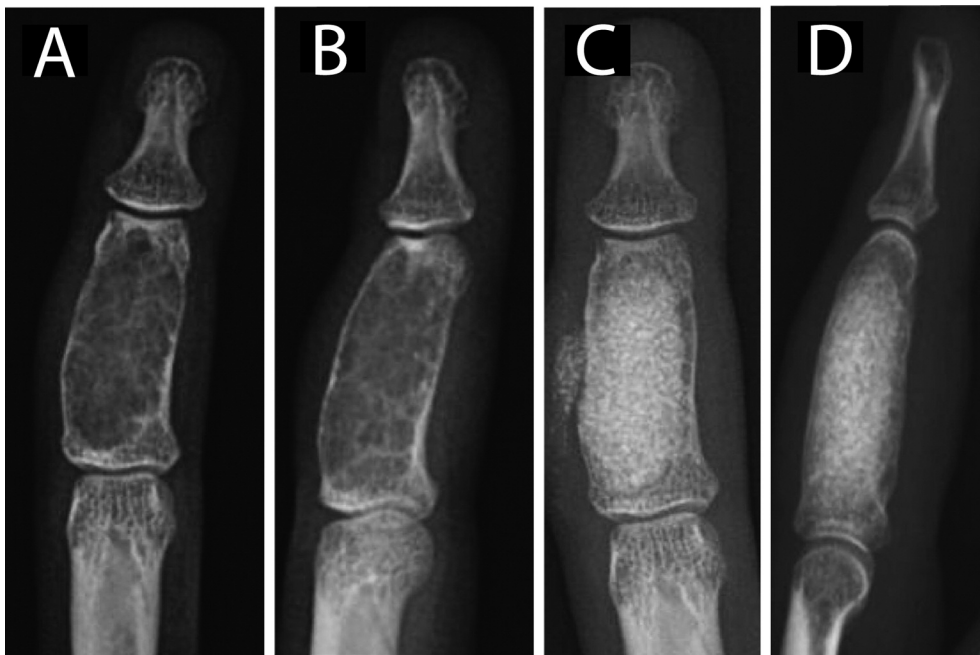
Plain radiographs from the case of a 19-year-old female with middle phalanx enchondroma at presentation (A and B), and at 6 months after treatment with curettage and bioactive glass filling (C and D). A small amount of the bioactive glass can be seen to have drifted outside of the cavity without any clinical relevance (C).
